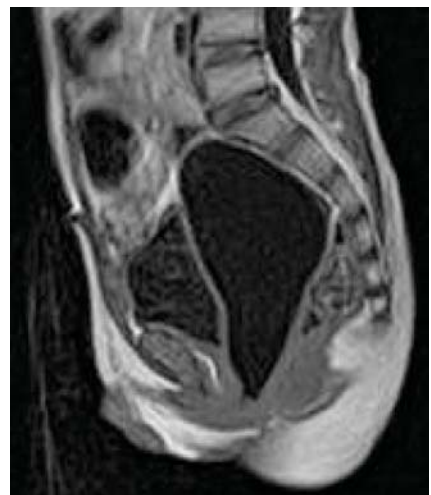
Sagittal T1 weighted MR image showing a well-defined, hypointense lesion posterior to urinary bladder and anterior to the rectum.
